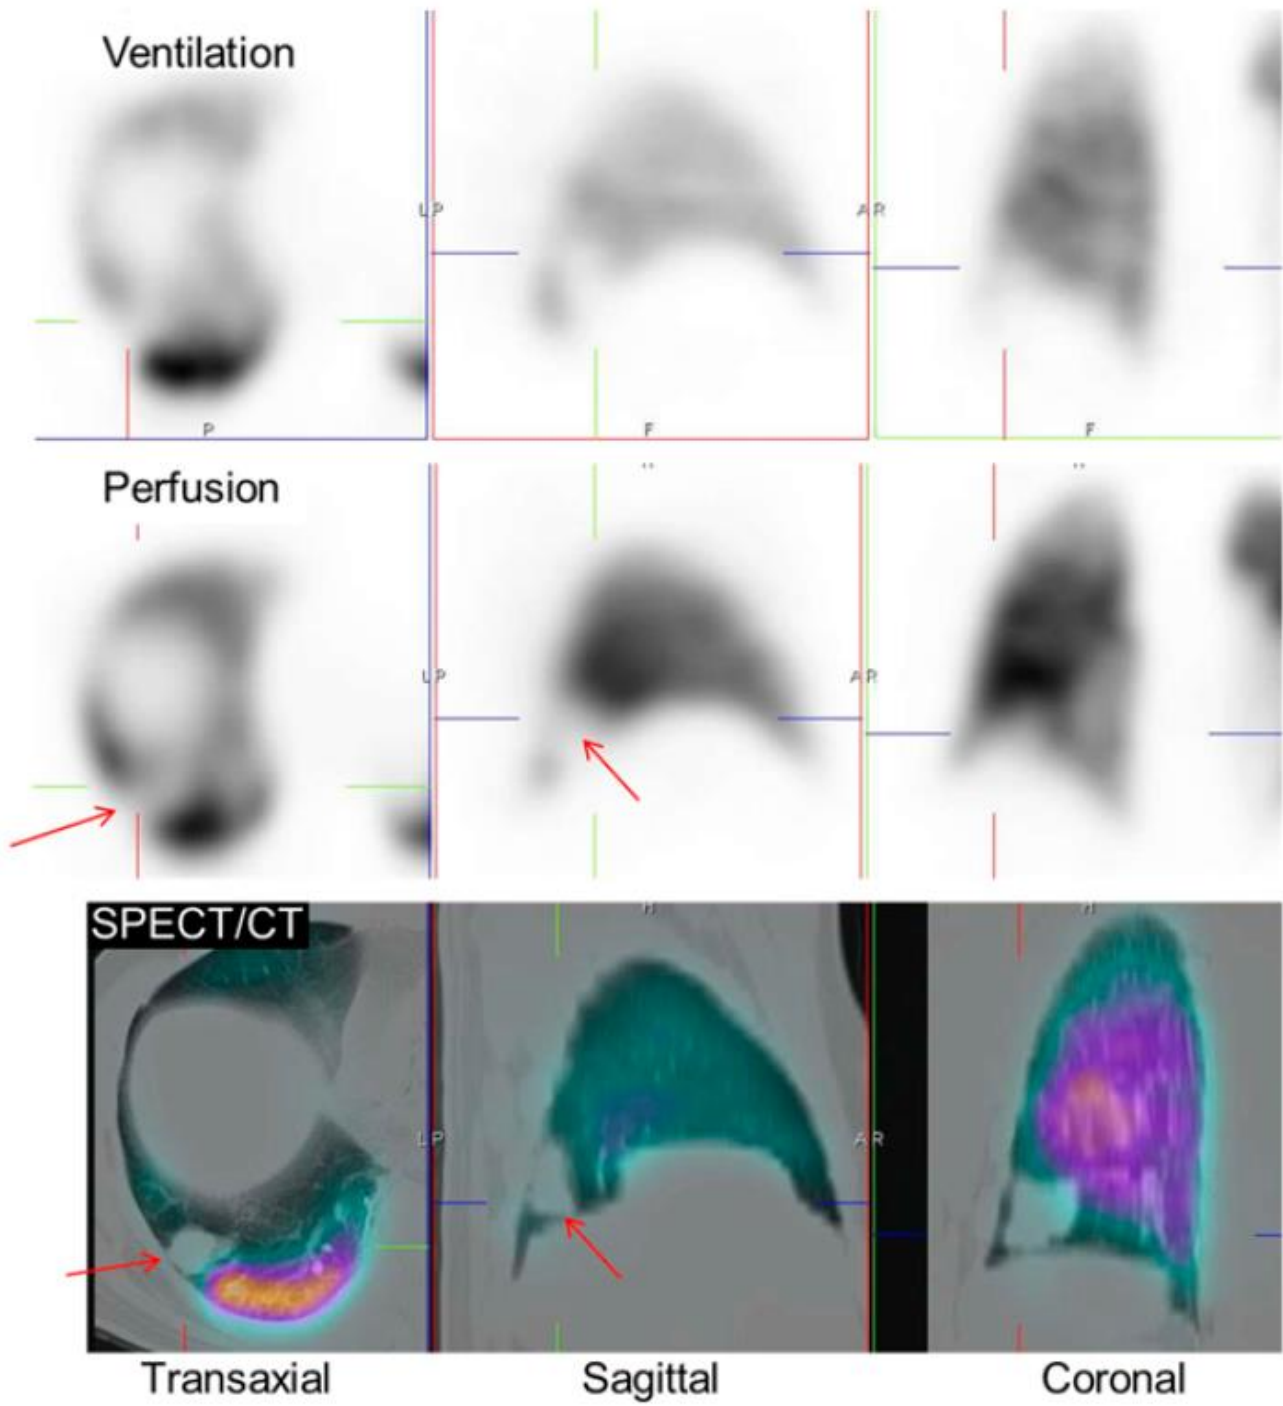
Fusion of SPECT and low dose CT showing an opacity (arrows) on the CT corresponding to the perfusion defect producing a matching defect consistent with lung metastases. Image with permission 5.
